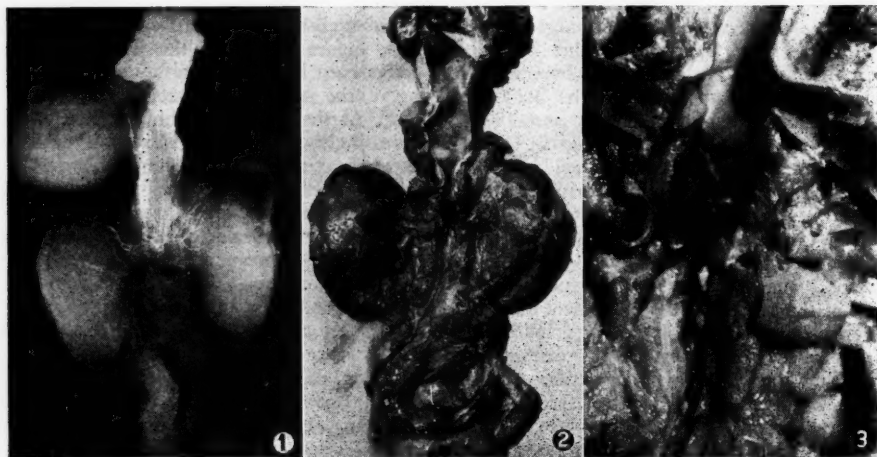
Post-mortem radiograph taken after injection of an opaque medium into the aorta. Note the hold-up of the dye proximal to the renal arteries.
